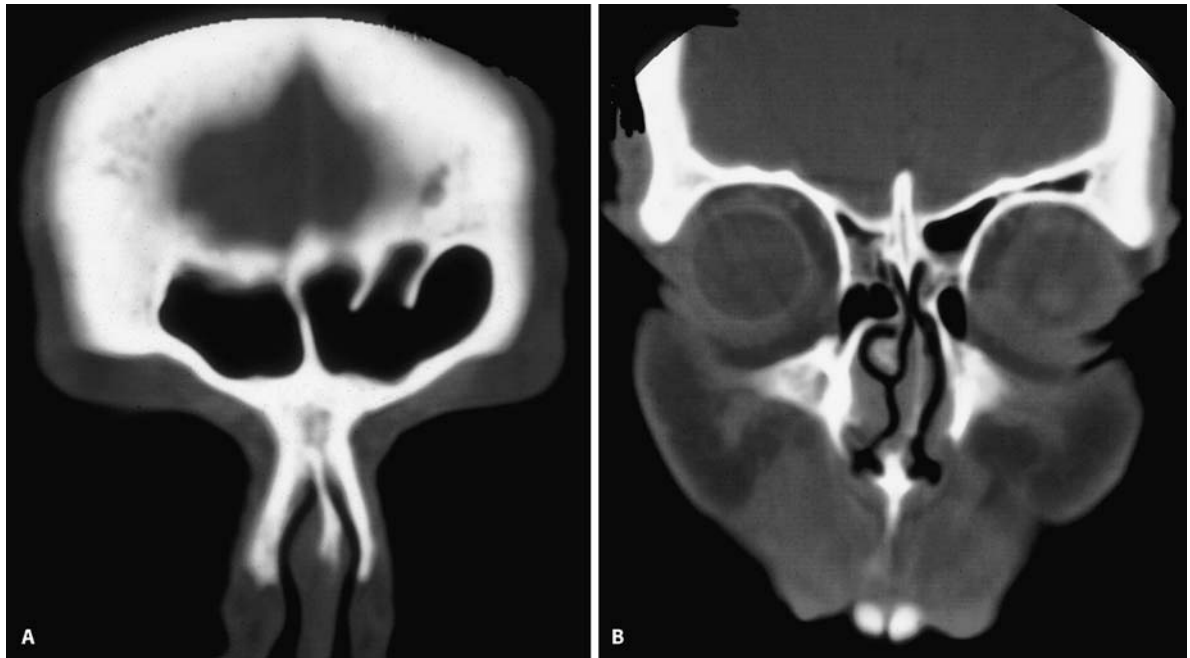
CT scan of a patient presenting with a 10-month history of right frontal headaches. A The frontal sinus appears aerated without disease. B A large, right agger nasi cell with secondary mucosal thickening within the frontal recess
